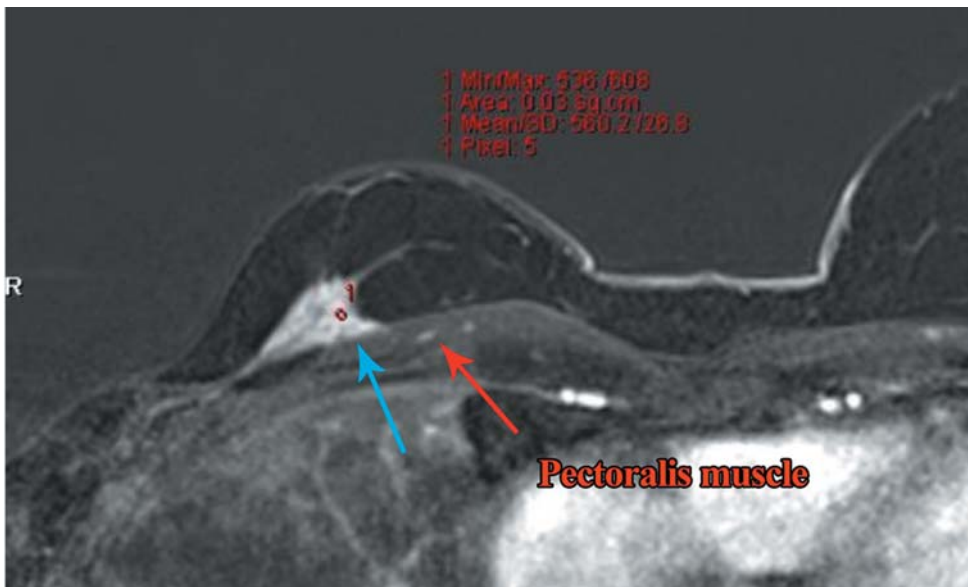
Results of pre-surgical magnetic resonance imaging (MRI) with contrast medium. MRI showed an oval mass with irregular margins, inhomogeneous enhancement of 33×16×20 mm (longitudinal). The finding is at the superior external quadrant, posterior third, in strict proximity to the pectoralis muscle that shows thin impregnation of 6 mm (blue arrow) that cannot exclude the infiltration of the muscle. Images are consistent with the written report signed by the M.D. specialist in Diagnostic Radiology.
